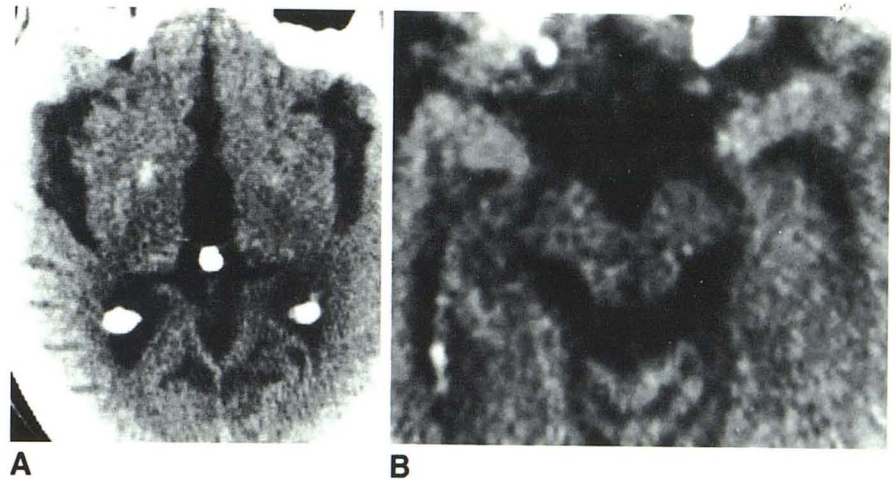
Case 2. A, CT scan through thalamus. Dilated third ventricle. B, Enlarged view. Atrophy of midbrain with dilated aqueduct, enlarged quadrigeminal plate cistern, and widened interpeduncular cistern.
